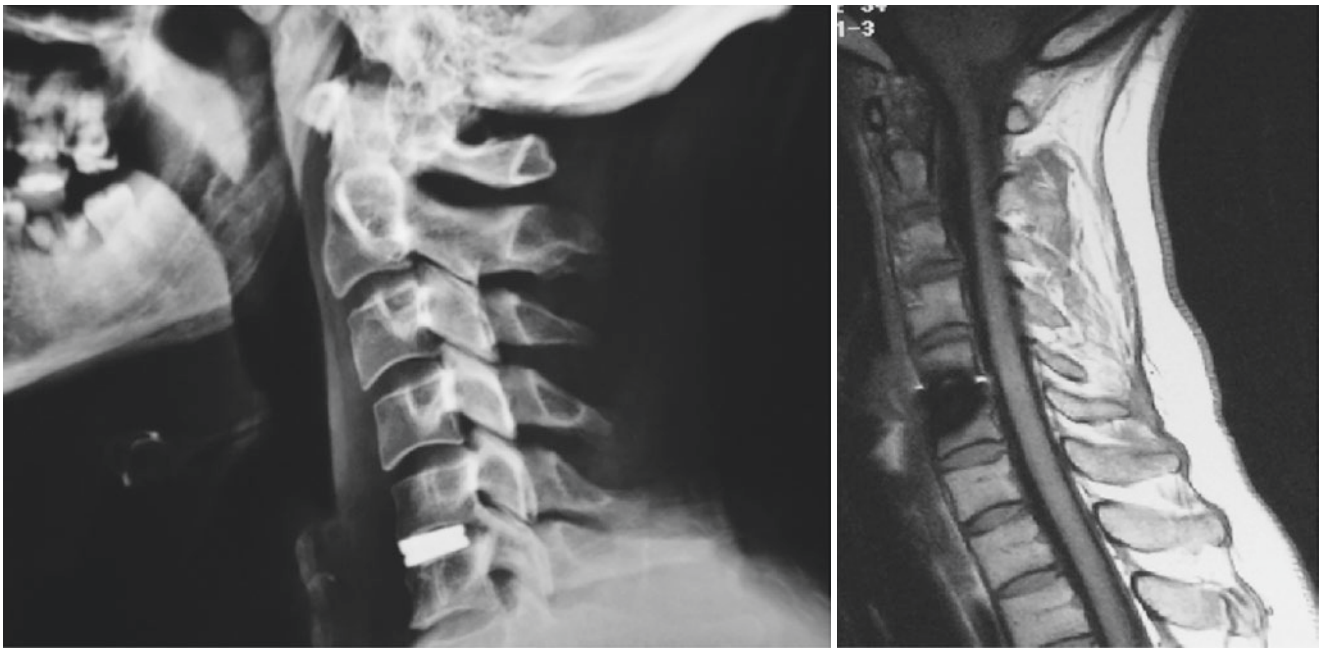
On the left, plain postoperative lateral X-ray at 6 months presenting the implant; on the right, in the same case, control T2-weighted sagittal MRI
